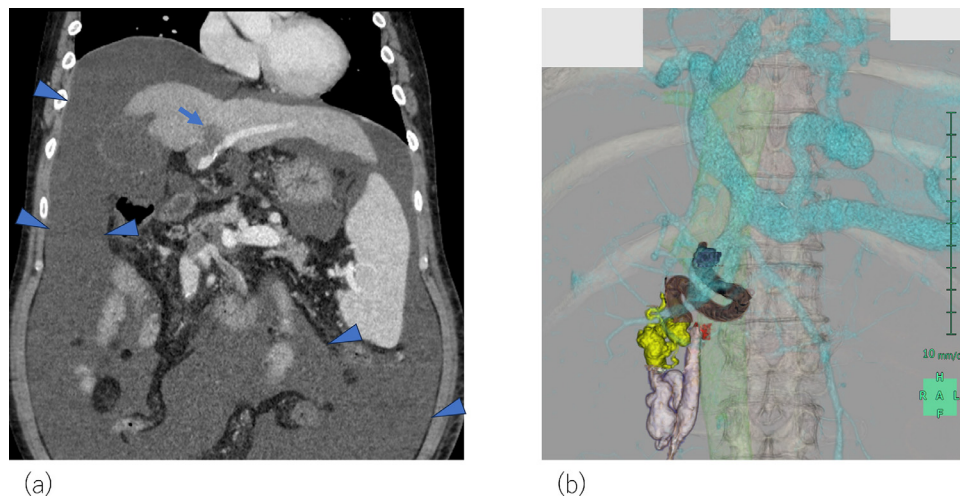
(A) Contrast-enhanced computed tomography image showing ascites (arrow head) and thrombosis of the umbilical portion of the portal vein (arrow). (B) Three-dimensional contrast-enhanced computed tomography image showing the portal venous system (light blue), duodenal varices (yellow), afferent vein (dark brown), efferent vein (grayish white) and junction of the efferent vein and inferior vena cava (red).
